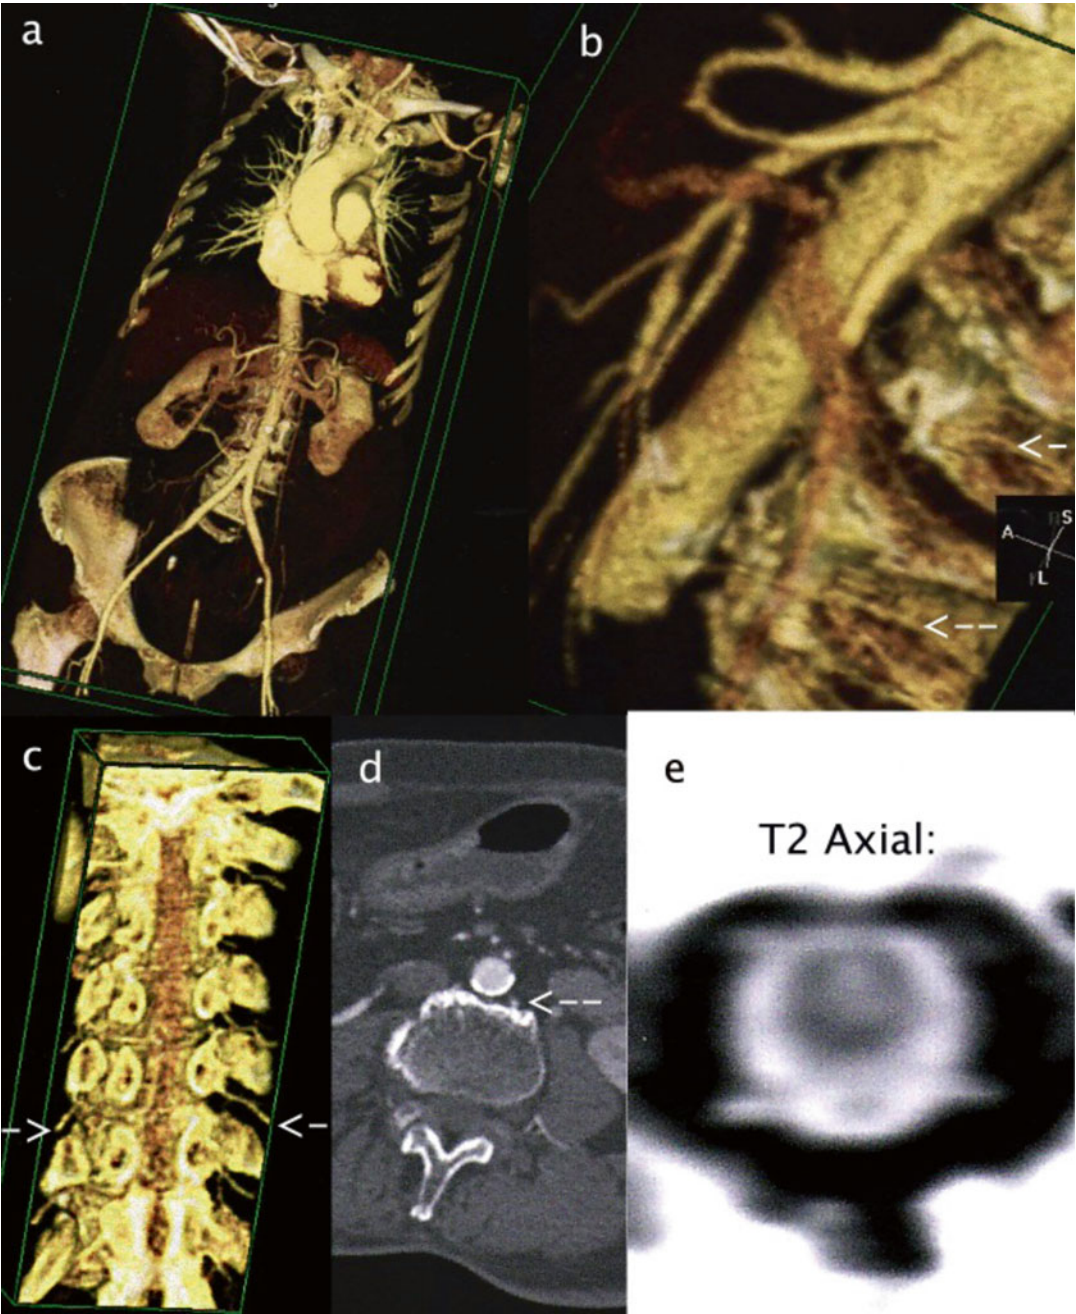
Anterior spinal artery ischemic change evident on axial T2 MRI with demonstration of radicular arteries
